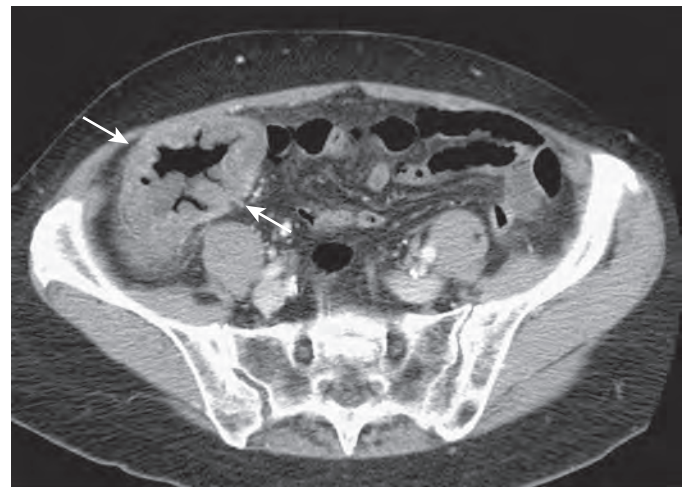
Typhlitis: CT features. Axial scan shows marked mural thickening of the cecum (arrows) in this patient with acute lymphocytic leukemia.
